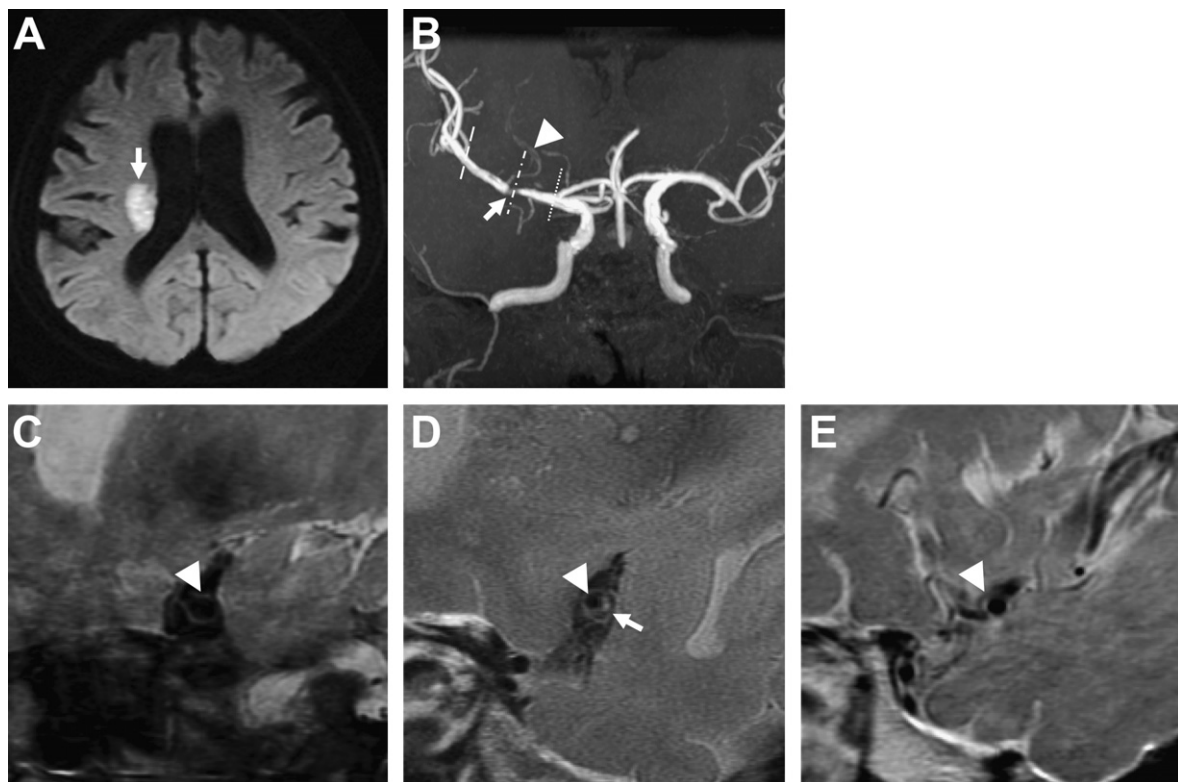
Case 1. (A) Axial diffusion-weighted MRI showing a high-intensity lesion of 20 mm in diameter in the right corona radiata (arrow). (B) Magnetic resonance angiography (MRA) image, processed by partial maximum intensity projection, indicating the relationship between the stenotic area (arrow) and lateral striate arteries (arrowhead). (C–E) High-resolution moderate T₂-weighted images obtained perpendicular to the right middle cerebral artery (MCA), at the level of the dotted line (C), the dash-dotted line (D), and the broken line (E) in B, showing the lumen of the right MCA (arrowheads). There were plaques on the vessel wall lumen of the right MCA at the level of the stenotic area observed with MRA (D, arrow), but no plaques at the level of the non-stenotic area (C, E).
